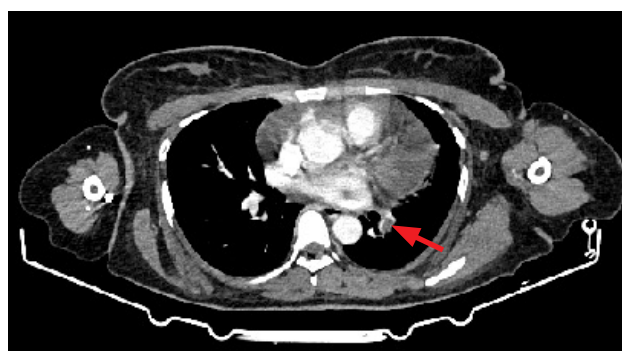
Axial CT scan shows a left lower lobe pulmonary artery embolus (red arrow).
